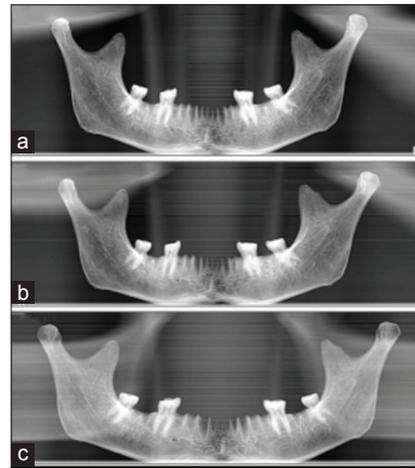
Panoramic radiograph of mandible having lesions on anterior surface on the right side and lateral surface of the left side. (a) Set 1, (b) Set 2, and (c) Set 3
